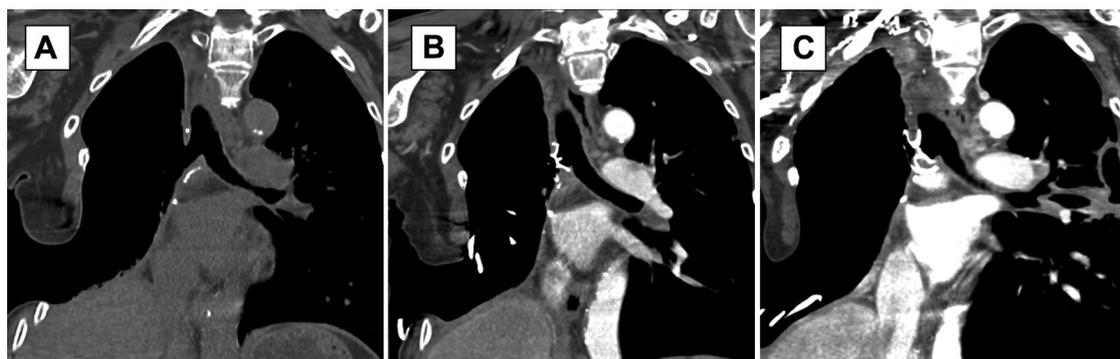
Chest computed tomography showing large bronchopleural fistula and open window thoracostomy (A), Amplatzer septal occluder shortly after its placement (St. Jude Medical, Minneapolis, MN) (B), and Amplatzer septal occluder at 16-month follow-up (C).
